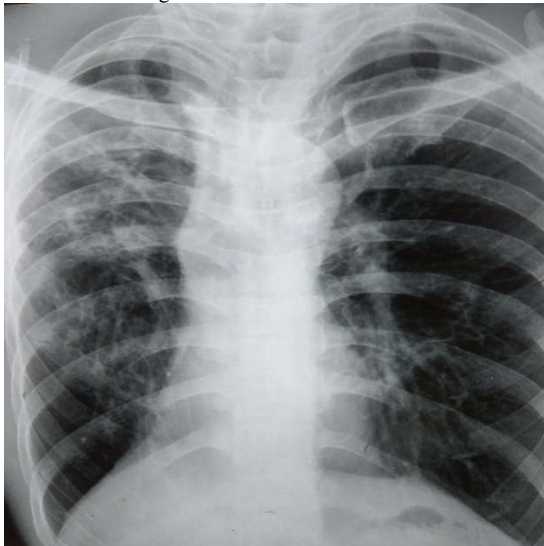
Chest X-ray PA view of 39 years male non-smoker with history of old healed pulmonary tuberculosis shows characteristic right upper and mid zonal fibrosis with ipsilateral mediastinal shift.
